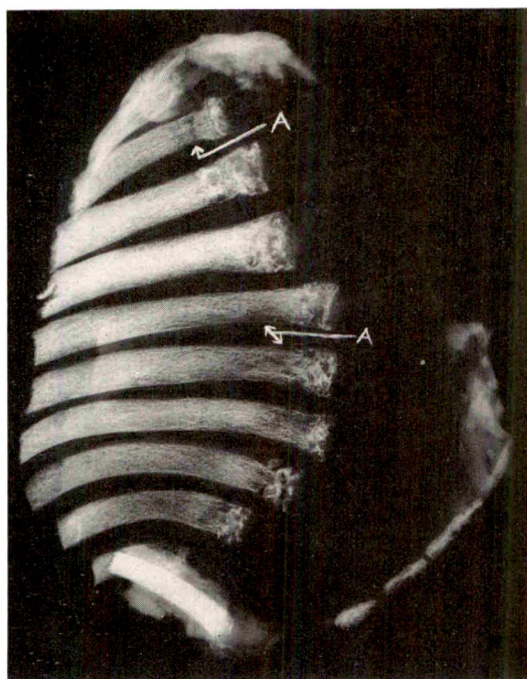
Case 1. Roentgenogram of ribs, post mortem, showing irregular mottling of anterior ends and defective subperiosteal calcification along the lateral margins.
